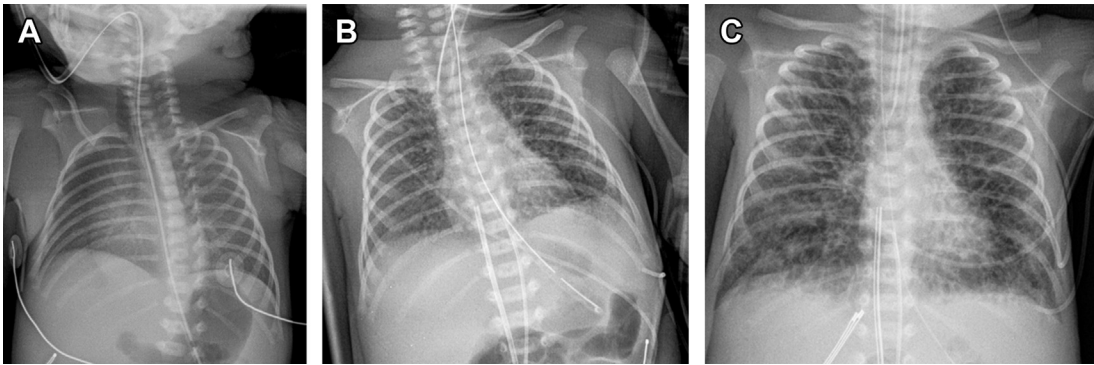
Newborn girl born premature at 29 weeks gestation with surfactant deficiency disorder and persistent pulmonary interstitial emphysema (PIE) (PPIE). (A) Chest radiograph at day 1 of life shows diffuse bilateral hazy pulmonary opacities of surfactant deficiency disorder. (B) Chest radiograph at day 2 of life demonstrates new bilateral bubbly and linear lucencies that do not conform to the shape of air-bronchograms, compatible with PIE. (C) Chest radiograph at day 9 of life shows persistent bubbly and linear lucencies of PIE, compatible with PPIE.
